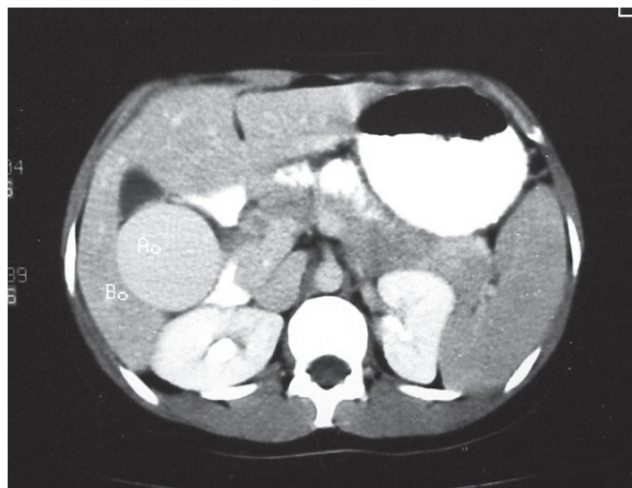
Computed tomography showing a portal vein dilation measuring 50 mm in diameter in the hepatic hilus. There is no thrombus inside. The spleen has a normal size. Performed in 1998.
